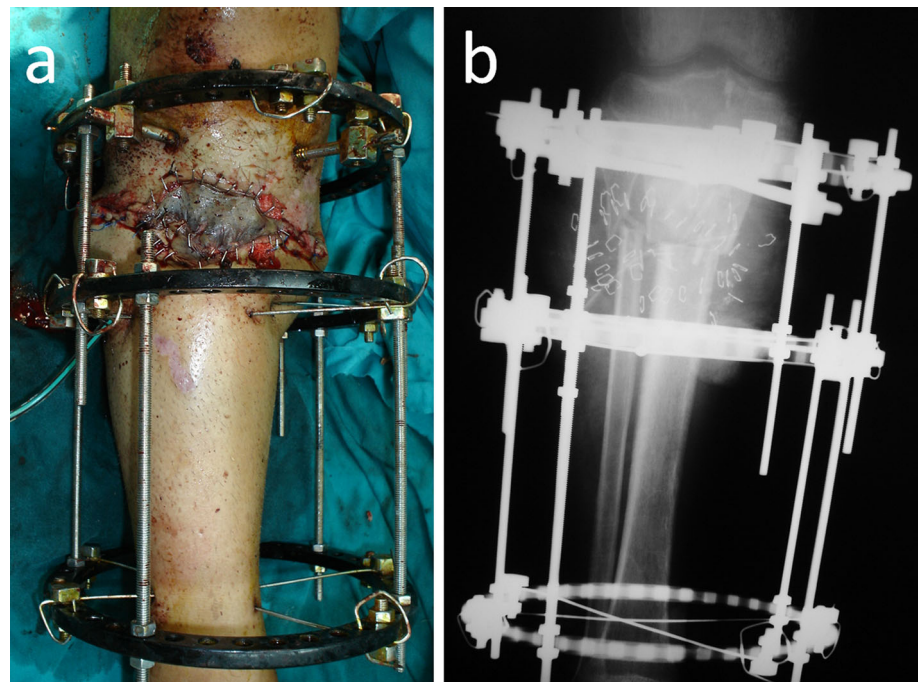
Clinical appearance of a patient with anterior soft tissue loss (a) and the preoperative radiographs b showing the underlying bone defect
